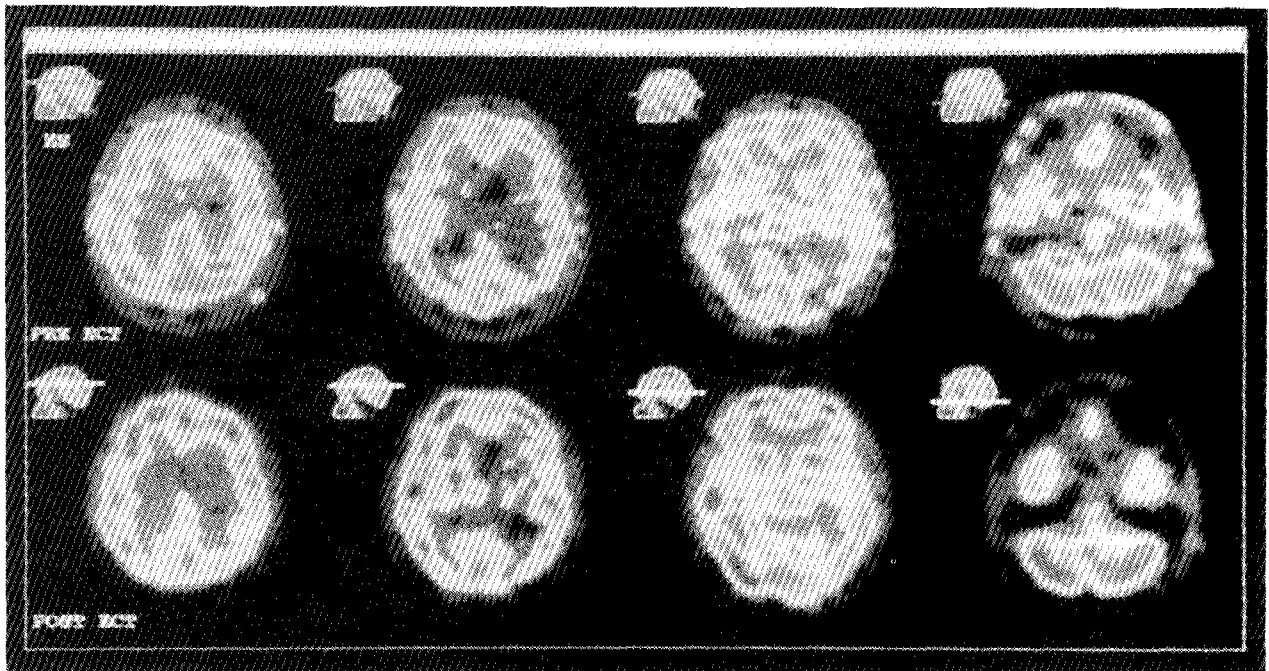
Male patient with depression exhibiting significant clinical improvement upon treatment with electroconvulsive therapy as seen in this SPECT study obtained following the administration of technetium-99m exametazime (transaxial view). [courtesy of Dr. Lukasz Konopka, V. A. Hines hospital and Loyola University Medical School, Maywood, IL]
